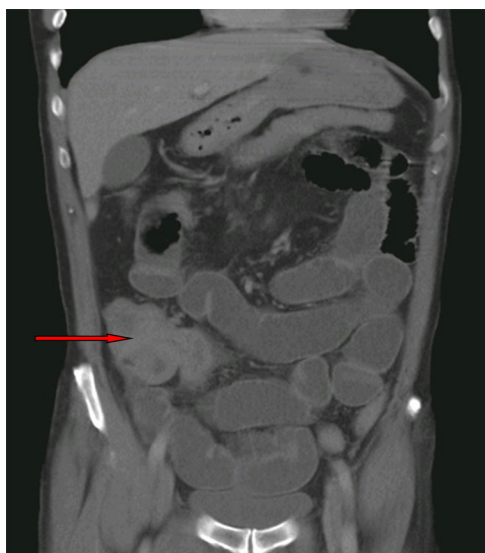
CT image at presentation demonstrating a large caecal neoplasm with concurrent small bowel obstruction.
